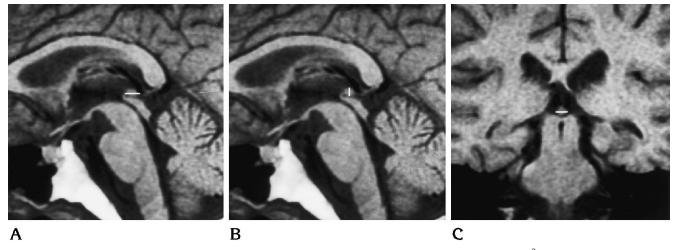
MR images of the pineal gland in a 19-year-old man with cerebral contusion (volume 68.3 mm<sup>3</sup>). A, The length of the pineal gland (*white line*) is 6.5 mm on T1-weighted sagittal image.
